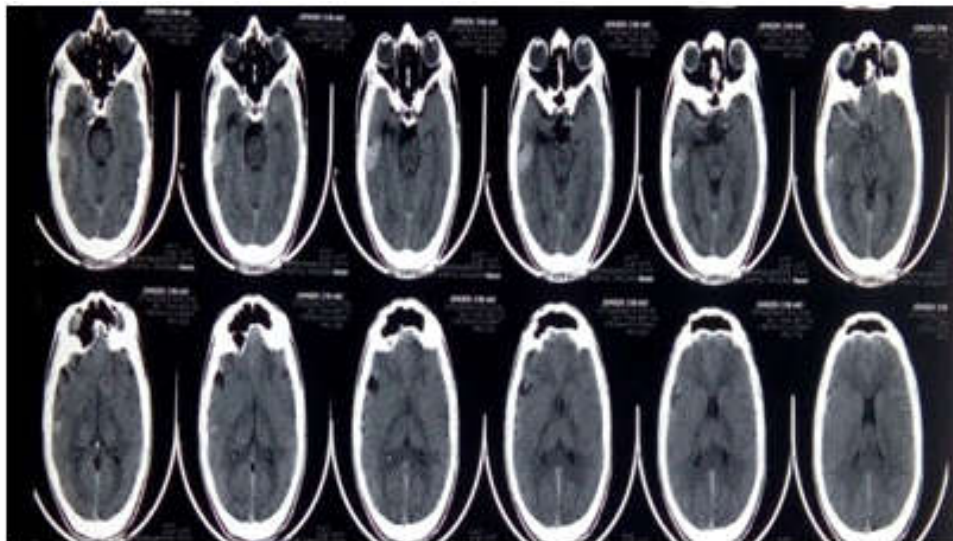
Case Report 3: (a). CT showing the Right Temporal hyperdense arteriovenous fistula varix
